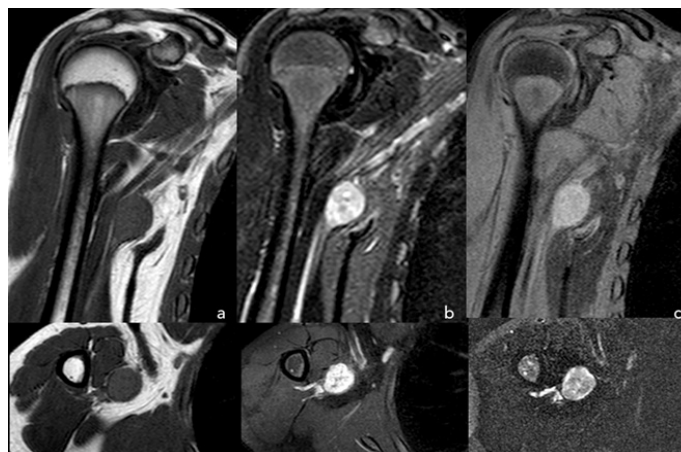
MRI appearance of axillary schwannoma of the patient. (a) T1-weighted; (b) T2-weighted; (c) STIR.
